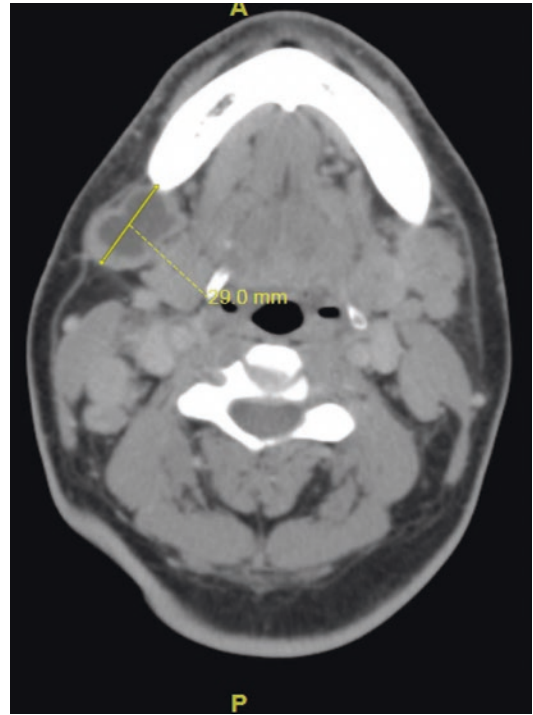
Axial CT slice demonstrating enlarged lymph node. (Courtesy Dr. Beomjune Kim)
